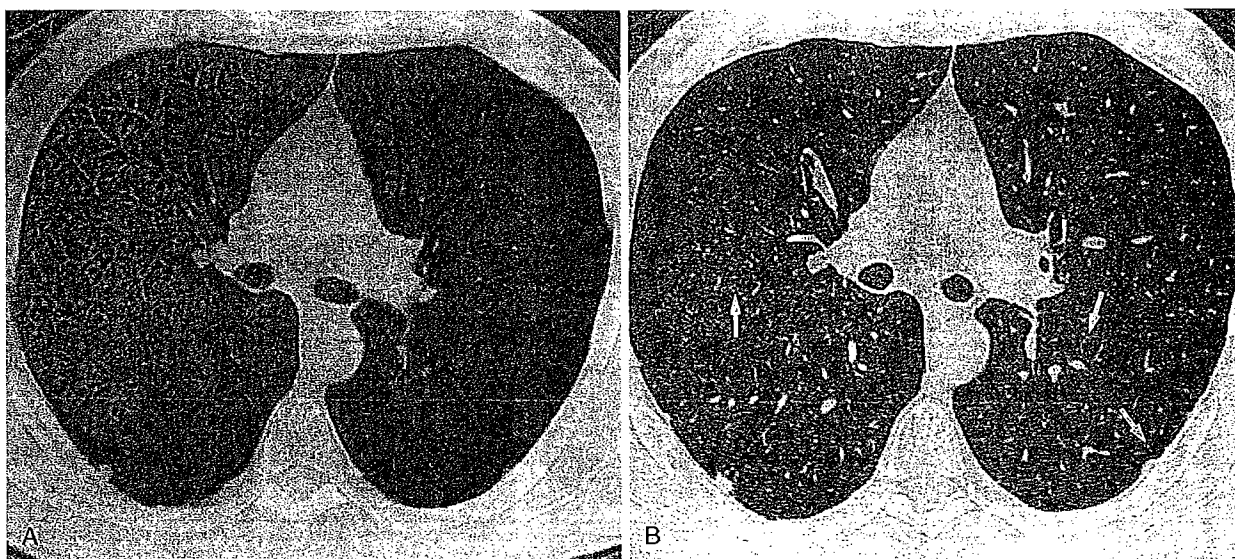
Coal Workers' Pneumoconiosis: Conventional CT and HRCT Findings. A conventional 10-mm collimation CT scan (A) demonstrates small nodules in both lungs. Subpleural nodules mimicking pleural plaques are also evident posteriorly. On HRCT (B), the nodules are more difficult to distinguish from vessels. The nodular and branching opacities, however, clearly have a centrilobular distribution (arrows). The subpleural pseudoplaques are also better defined on the HRCT image. (Courtesy of Dr. Martine Remy-Jardin, Centre Hospitalier Regional et Universitaire de Lille, Lille, France.)
